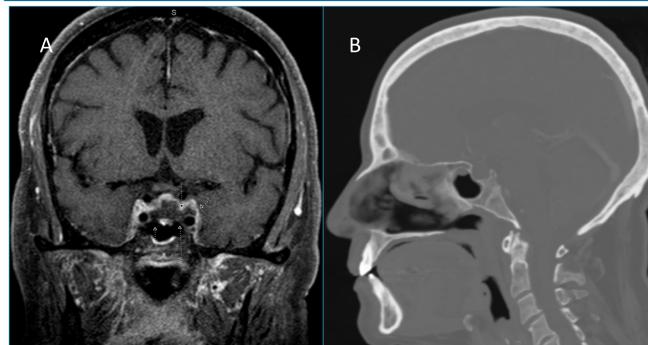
Imaging of case 1. A. Coronal T1W MRI showing hypointense lesion within sella extending to the left cavernous sinus. B. Sagittal CT showing an intact sella with no dehiscence or erosion of bone. Sphenoid sinus shows mucosal thickening.
